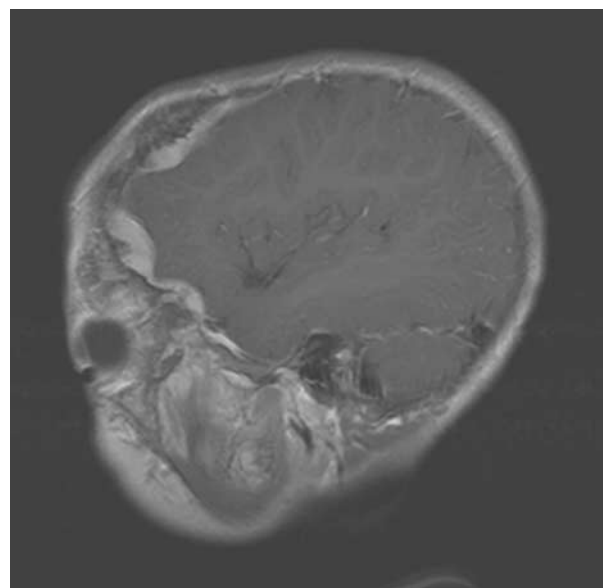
Meningeal metastases of patient 6. Sagittal T1 weighted MRI of patient 6 at diagnosis, showing meningeal and bone metastases. MRI indicates magnetic resonance imaging.
